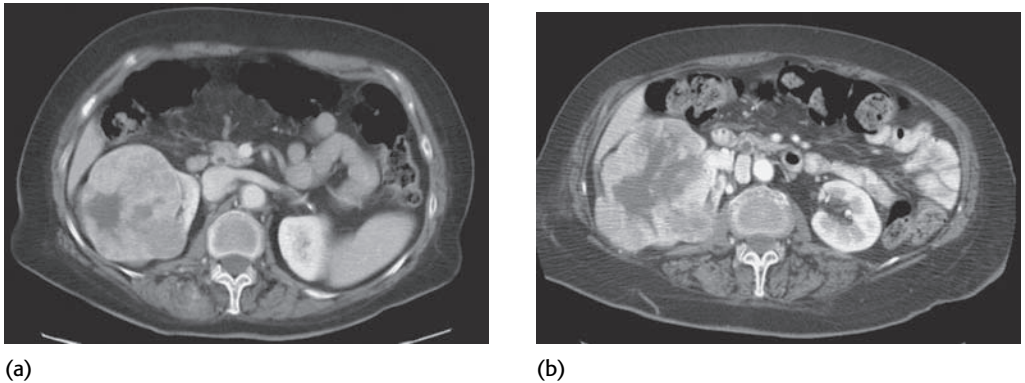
Slow growth of a large renal cancer. (a) A large heterogeneous renal cancer was identified in this patient. The patient was not an operative candidate because of co-morbidity, so the patient was observed. (b) A follow-up CT performed more than 2 years later shows that the mass has increased in size, although the interval change has not been dramatic.
